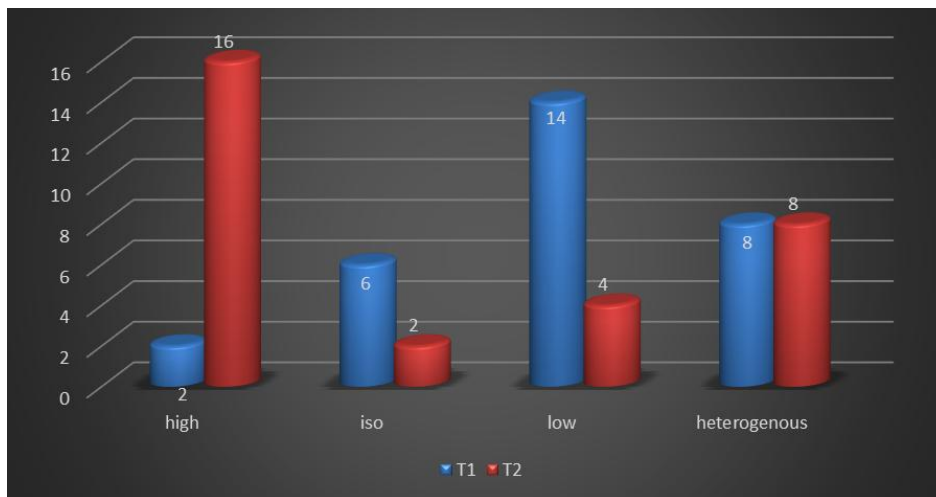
The signal intensity of the 30 analyzed lesions on T1 and T2 WIs in pre-TACE MRI studies
